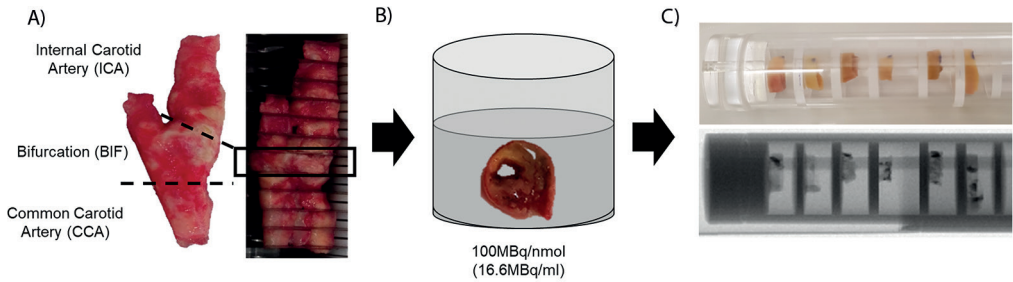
A) Carotid plaque sample sectioned into 2 mm segments, B) incubation step involved immersing segment in mixture of dual-radiotracers [¹¹¹In]In-Danbirt) and [^{99m}Tc]Tc-Demotate 2 and C) live and x-ray view of plaque segments (2 mm) mounted on a custom made holder for dual-isotope acquisition SPECT/CT scanning.
